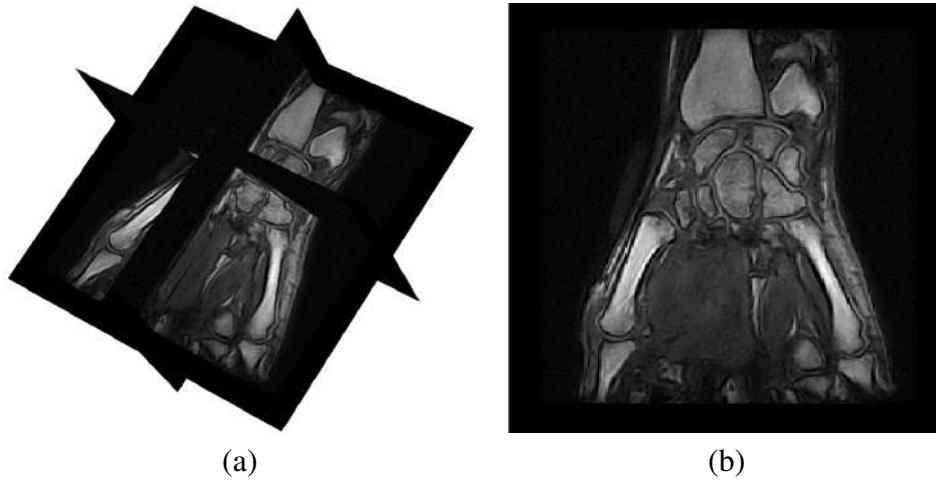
T_1 - *weighted* low field MRI of the carpal district. (a) 3D view, (b) 2D slice representation.
